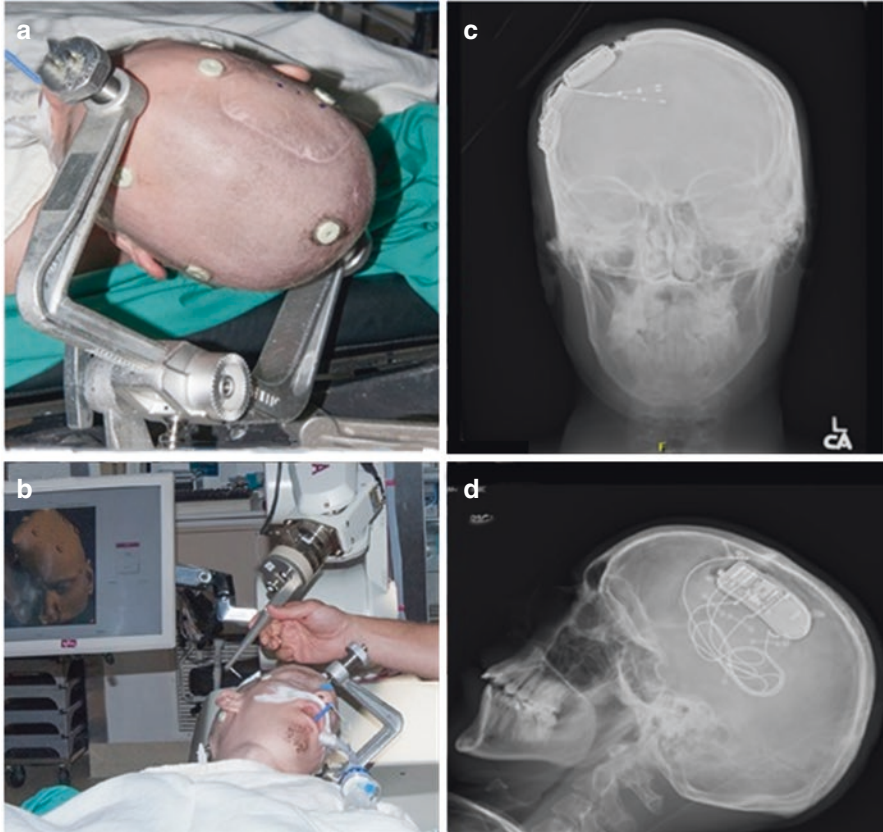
Robotic implantation of response neuro stimulation device. (a) Head position using Mayfield head holder. (b) Robotic registration using scalp fiducials. Panels (c) and (d) showing AP and lateral postimplantation RNS device X-rays using the robotic technique
